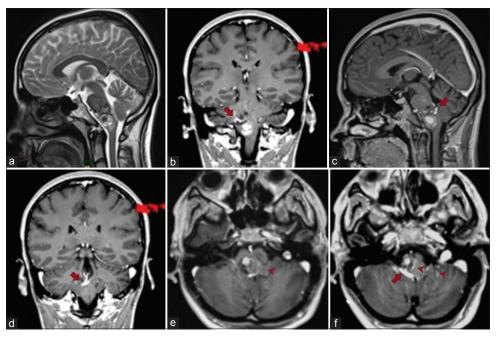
(a) Magnetic resonance imaging T2-weighted sagittal image shows pontomedullary cavernoma after recent bleeding, (b-d) magnetic resonance imaging T1-weighted images with gadolinium. Medullary veins of the pontomedullary developmental venous anomaly exits dorsally to the cavernoma in a large collecting vein near the floor of the fourth ventricle (arrows), and (e and f) magnetic resonance imaging T1-weighted axial images with gadolinium. Transparenchymal small veins – tributaries of the developmental venous anomaly (arrowheads). A large collector draining vein running toward the cerebellomedullary fissure (arrow)
